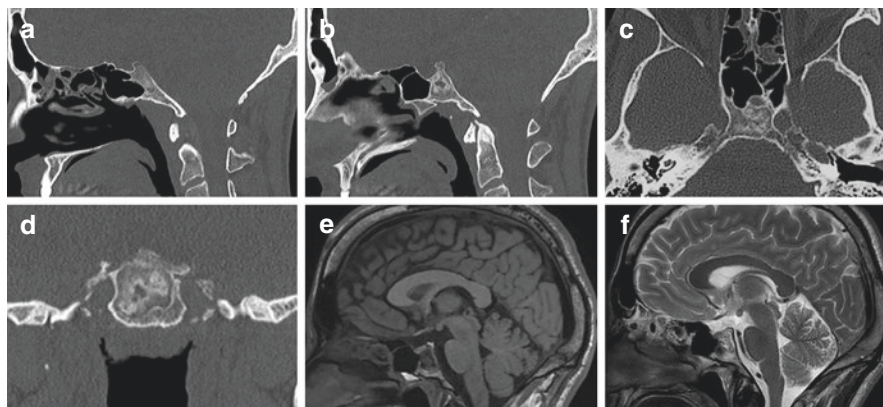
Clival fibrous dysplasia. CT (a–d) and MR (e–f)
